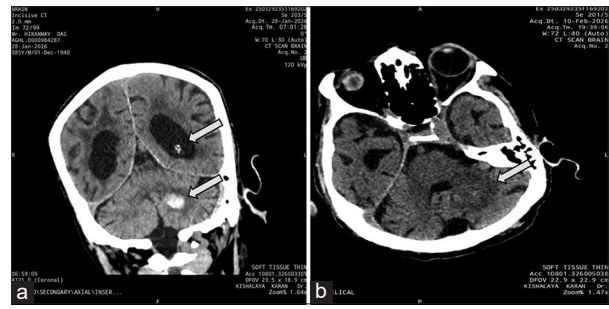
(a) CT scan of brain showing hematoma at left cerebellar hemisphere (lower arrow), significant supratentorial ventricular dilatation with small intraventricular haemorrhage and diffuse cerebral atrophy with bilateral periventricular deep white matter ischemia (upper arrow). (b) CT scan of brain showing minimal residual hematoma with surrounding oedema/hypointensity in the left cerebellar hemisphere
